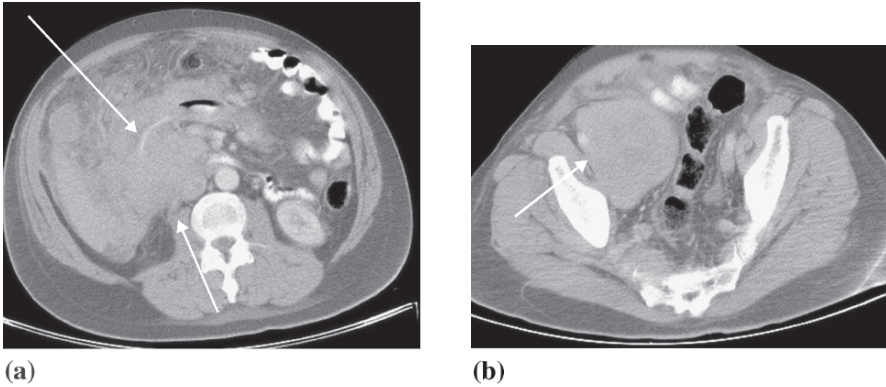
Axial CT images of a 56-year-old patient with a known diagnosis of non-Hodgkin's lymphoma. (a) The lymphadenopathy has conglomerated to form a soft tissue mass compressing part of the small bowel with infiltration of the bowel wall. (b) This image shows a large soft tissue mass in the pelvis that represents enlarged lymph nodes. This mass displaces the bowel and the right external iliac artery
